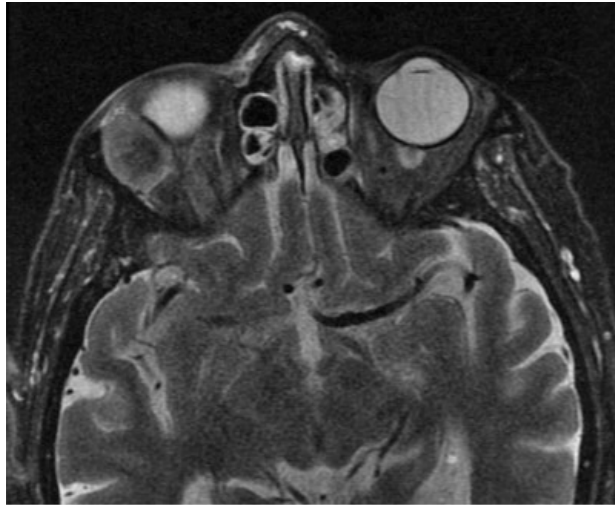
T2-weighted MRI of the orbits demonstrating right lacrimal gland mass with indentation of the globe.
